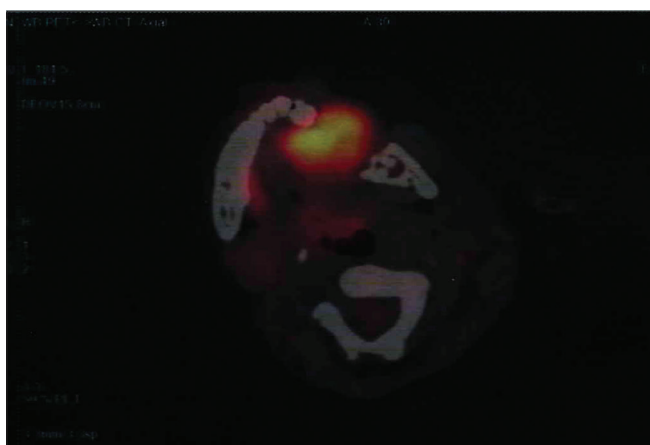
PET scan with 18 FDG uptake involving left body of mandible showing increased proliferative mass with bony erosion (SUV max = 8.0)
